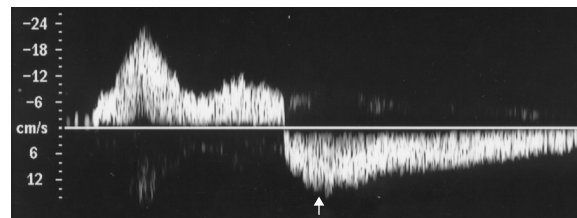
Doppler waveform demonstrating the effect of respiration (indicated by the arrow) and the cardiac cycle (indicated by the bracket) on the blood flow in a subclavian vein.
